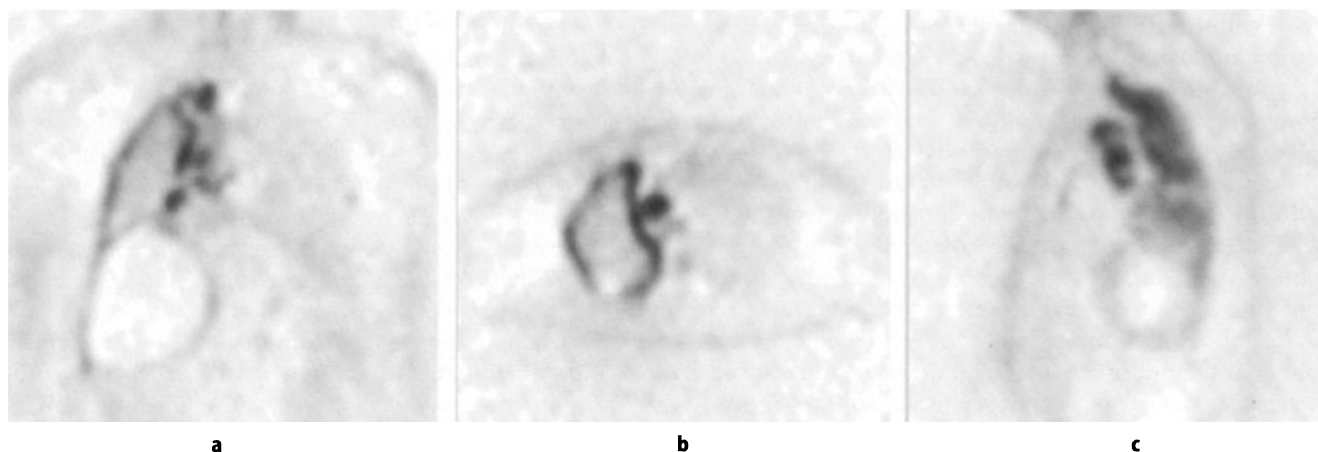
^{18}F FDG PET in malignant mesothelioma. Coronal (a), transaxial (b), and sagittal (c) tomographic images show marked uptake around the right lung, and in several metastatic foci in right hilar nodes. (Courtesy of the Department of Nuclear Medicine, McMaster University Medical Centre, Hamilton, Canada.)
